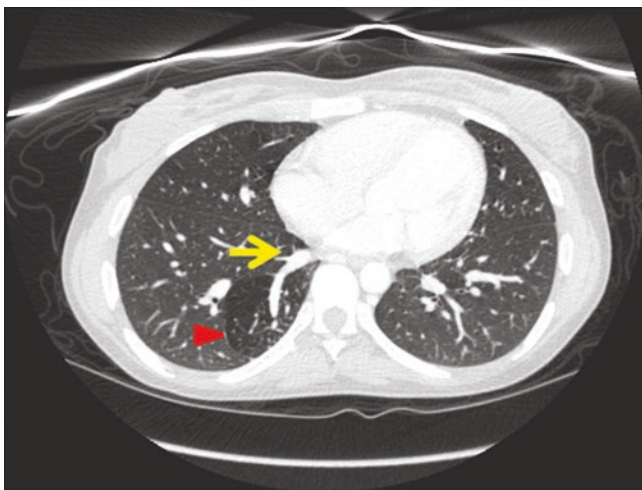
CT imaging findings in extralobar sequestration. Notice the presence of a discrete pleural envelope surrounding the lesion (red arrowhead), as well as the discrete feeding vessel penetrating the lesion (yellow arrow)
